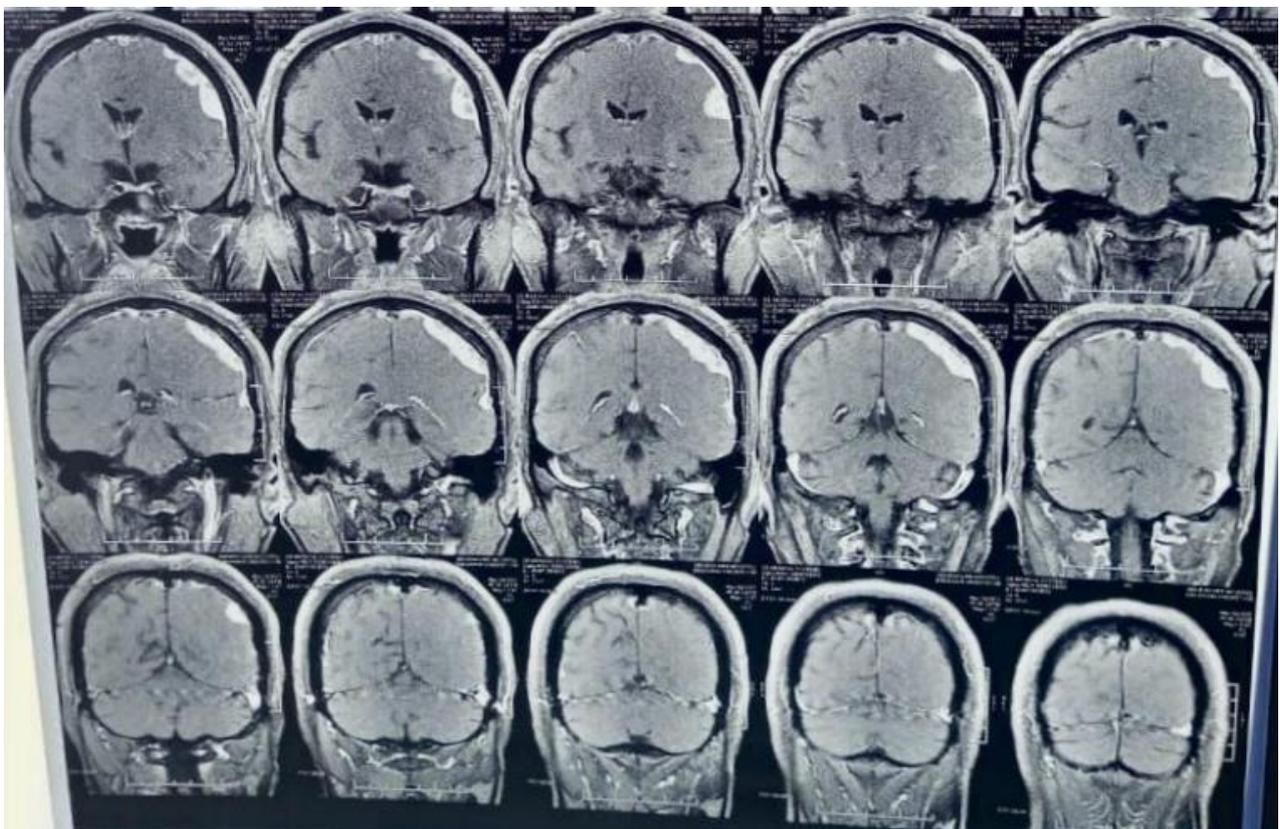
MRI Brain T1 weighted Post Contrast Image.
